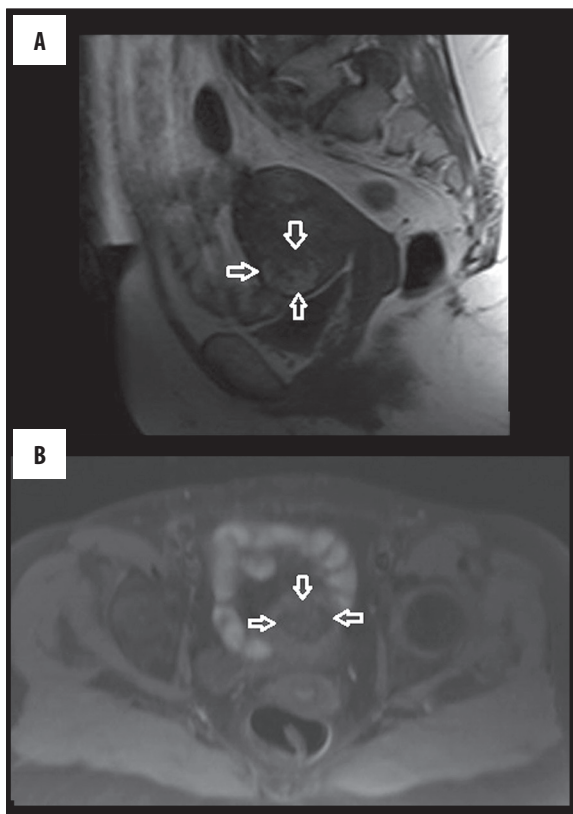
Sagittal T2-W MR image shows a well-defined heterogeneous hyperintense mass (arrows).
